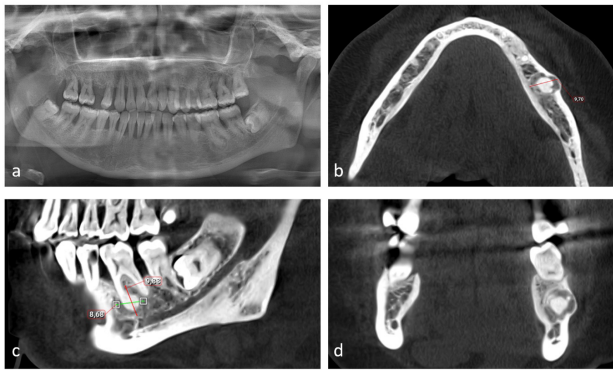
a. Panoramic radiography of the third follow-up session (year 2022), b. Increased hyperdense content and expansion in the buccal plate, c. Minimally enlarged dimensions of the lesion. No signs of infection. Lesion is not in close relation with mandibular canal. D. Coronal plane shows hyperdense lesion surrounded by hypodense area in the left mandibular first molar region with thinning of the buccal cortical plate.
